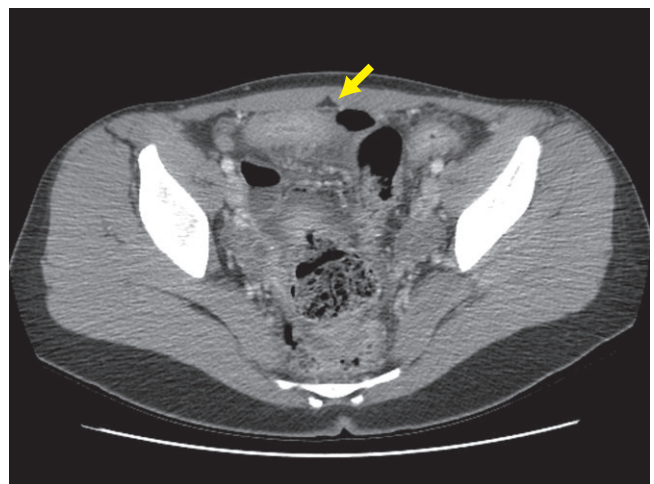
Corresponding CT scan demonstrating thickening of the small bowel (arrow).
